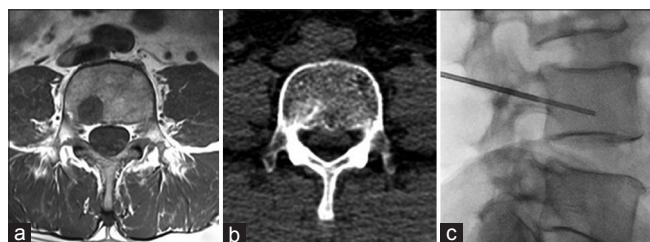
Fluoroscopy-guided vertebral biopsy in a 63-year-old male with lung adenocarcinoma. T1-weighted axial magnetic resonance image of a 2-cm hypointense mass in L4 vertebral body (a). Axial computed tomography scan of sclerotic lesion in the corresponding area of the L4 vertebral body (b). Percutaneous biopsy performed with a right transpedicular approach under fluoroscopic guidance (c). Biopsy confirmed the diagnosis of metastasis from lung cancer
